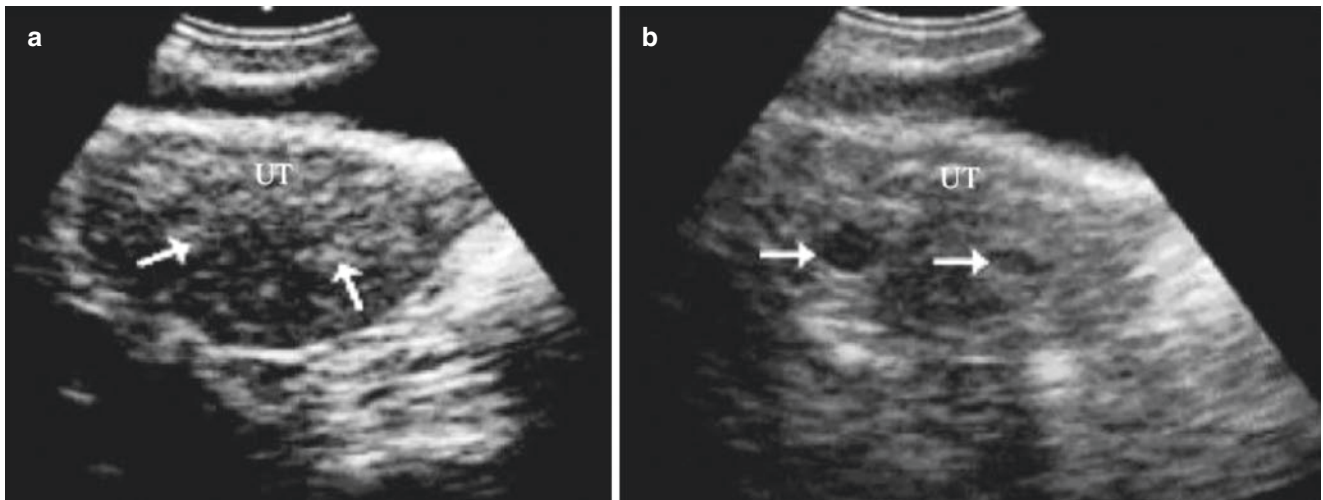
Sonohysterography of the incomplete uterus septum. (a) The patient is 30 years old, and uterus septum is suspected by ultrasound examination; (b) After injection of contrast agent, the left uterine
